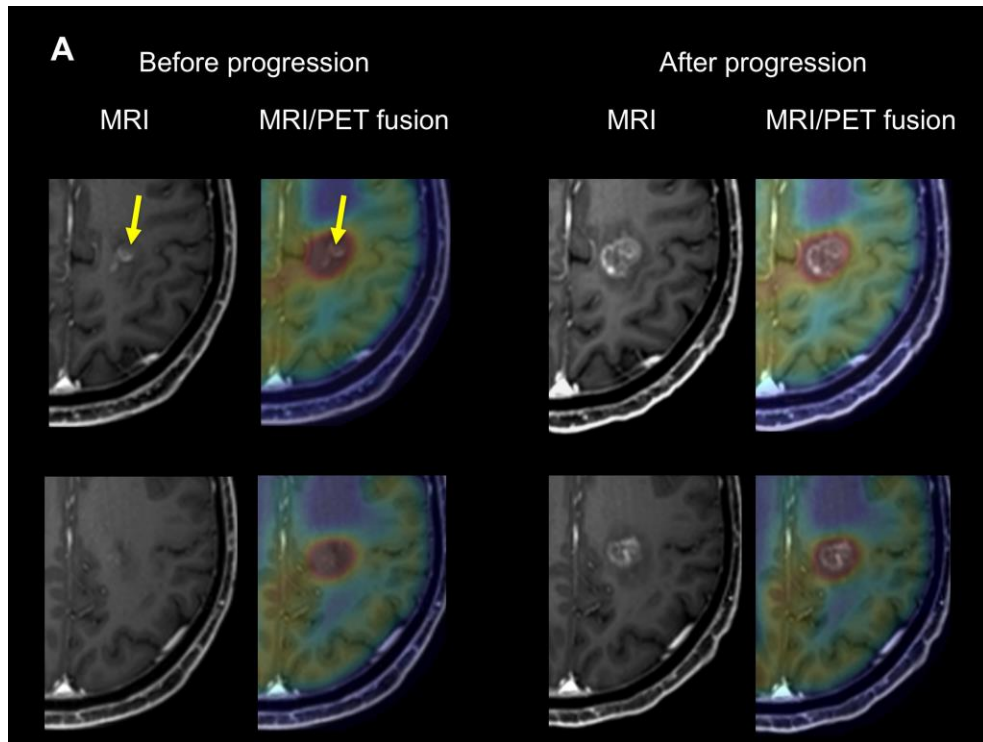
T1-Gad MRI and co-registered MRI/AMT-PET fusion images of patient showing a left medial fronto-parietal contrast-enhancing lesion (arrows) suspicious for glioblastoma recurrence 4 months after initial treatment. High AMT uptake was seen in the same region (upper panel), extending superior (and also inferior and lateral) to the contrast-enhancing lesion (lower panel), with an SUV_{max} of 4.7. After MRI progression, 1 month later, the Gad+ mass grew into and filled the original PET+/Gad- area.
